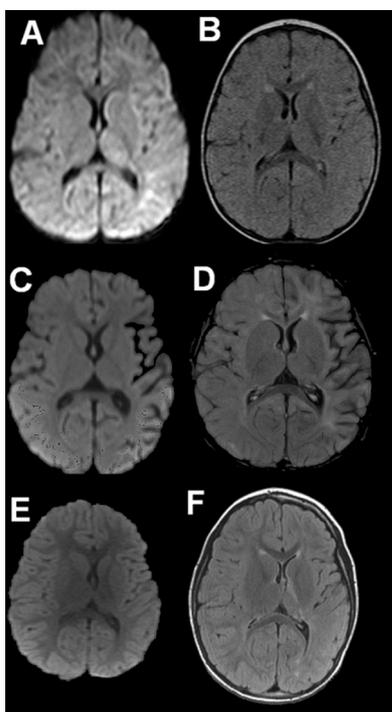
Magnetic resonance imaging. (A) Axial diffusion-weighted imaging in child with hemiconvulsions, hemiplegia and epilepsy on day 1 of hospitalization shows restricted diffusion in the left hemisphere, resulting in hyperintense signal changes, especially in the thalamus and parieto-temporo-occipital regions. (B) Fluid attenuated inversion recovery images on the same day show subtle increase in signal over the left hemisphere. (C and D). Diffusion-weighted imaging and fluid attenuated inversion recovery images after 3 wk show atrophy of the left hemisphere, especially in the perisylvian regions. (E and F) Diffusion-weighted imaging and fluid attenuated inversion recovery images after 3 yr show a left hemisphere that is smaller than the right.
